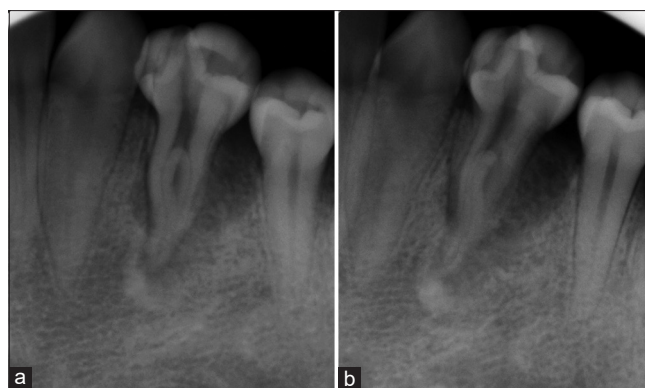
Preoperative periapical radiographic image of mandibular first premolar #34. (a) Straight angulation radiograph. (b) Angulated radiograph
